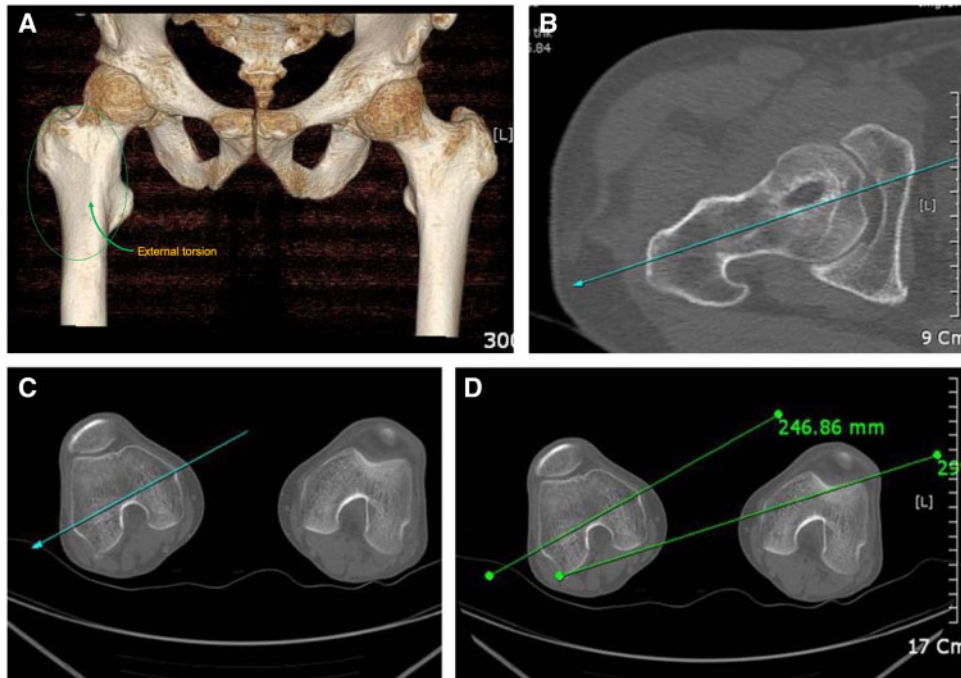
(A) The orthogonal 3D CT view of femur neck and trochanter showed the external torsional deformity. (B) Right femur neck axis. (C) Right distal femur trans-epicondylar axis. (D) The right distal femoral transepicondylar axis was externally rotated by 10° compared with the right femur neck axis, which meant femoral retroversion.
